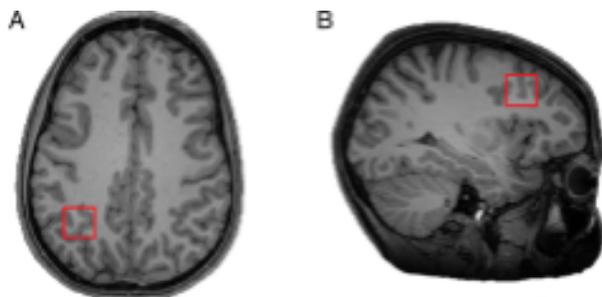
This figure, produced by the researchers using a standard display of MRI images of the brain from different perspectives, shows (A) the IPS and (B) MFG regions.
